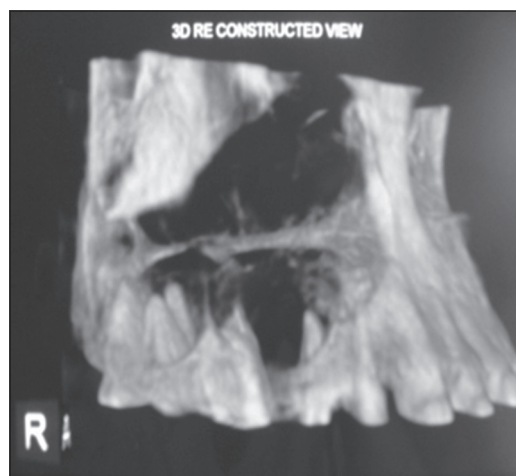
Three-dimensional view of computed tomography scan depicting invasion maxillary sinus
